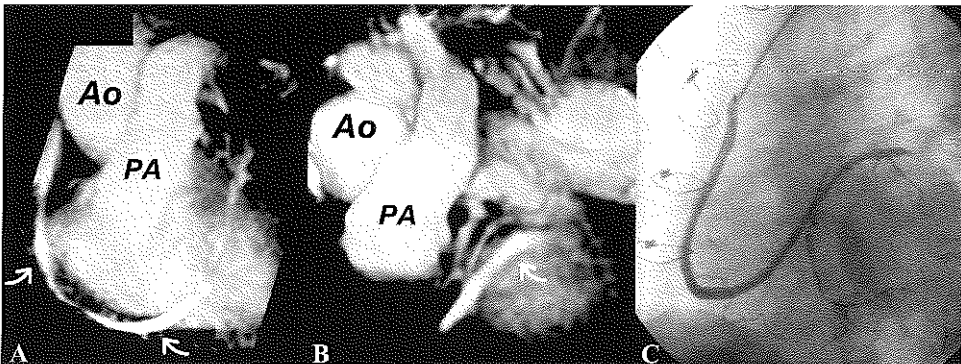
(A) MRI image of a partially occluded venous graft. The proximal segment to the first anastomosis is patent (curved arrows) while the second segment is patent but with diminished image quality. (B) Second MRI volume targeted for the third anastomosis demonstrating the occlusion of the graft distal to the anastomosis. (C) Corresponding conventional coronary angiography confirming the patency of the proximal graft segments, the diseased third segment and occluded distal segments.
